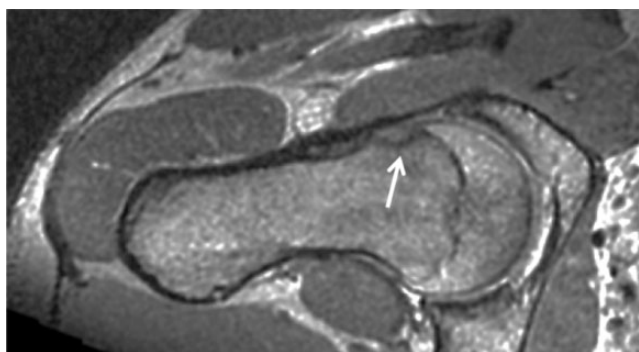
Magnetic resonance image of the right hip of a 20-year-old female alpine skier with a cam lesion (arrow).
